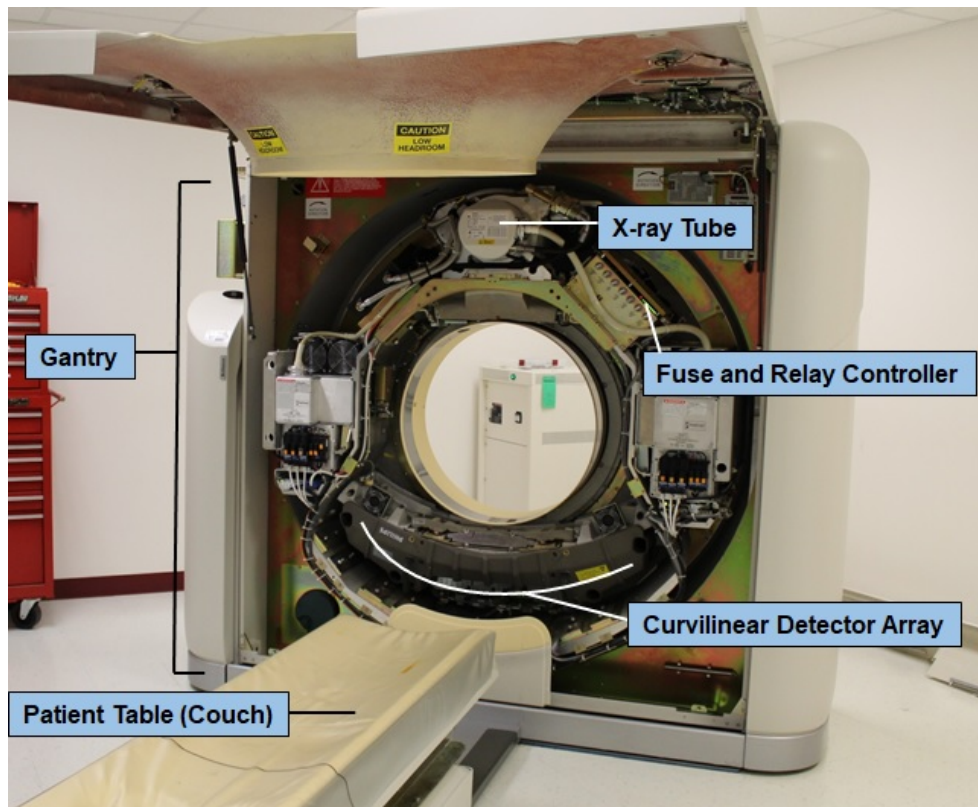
Third generation CT components.
